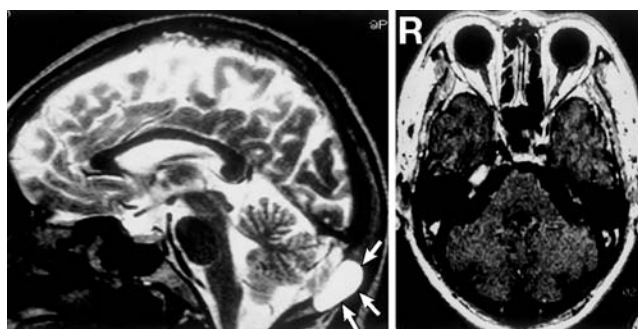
left: Midsagittal T₂-weighted magnetic resonance (MR) image showing a cystic lesion in the suboccipital region (arrows). right: Axial T₁-weighted MR image with gadolinium revealing no enhancement of the lesion.
